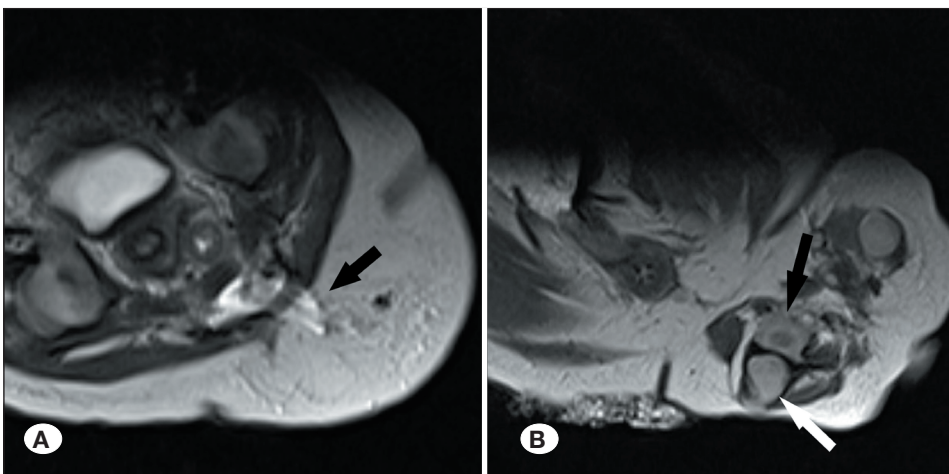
A) MRI-T2 weighted axial sections showing spinal cord roots protruding posteriorly at the S2-3 vertebral level (black arrow); B) A rudimentary bowel loop (white arrow) and uterus and vesicle sacs (black arrow) are visible.
